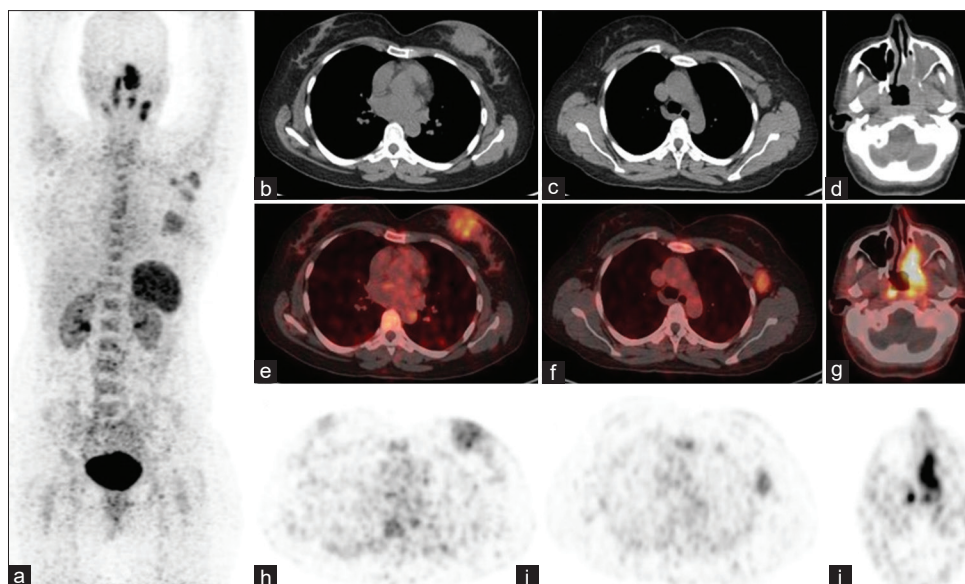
MIP image of CXCR-4 PET/CT demonstrated multiple tracer avid lesions. On transaxial images, mild increased tracer is localized to the left breast lesion (b-d) and left axillary and sternal lesion (e-g). In addition, intense CXCR-4 expression was noted in the nasopharyngeal lesion (h-j) and had a SUVmax value of 12.2. In view of clinical and imaging suspicion of a synchronous second primary in the nasopharynx, she underwent pathological confirmation, which demonstrated lymphoepithelial nasopharyngeal carcinoma (Schminke type)
